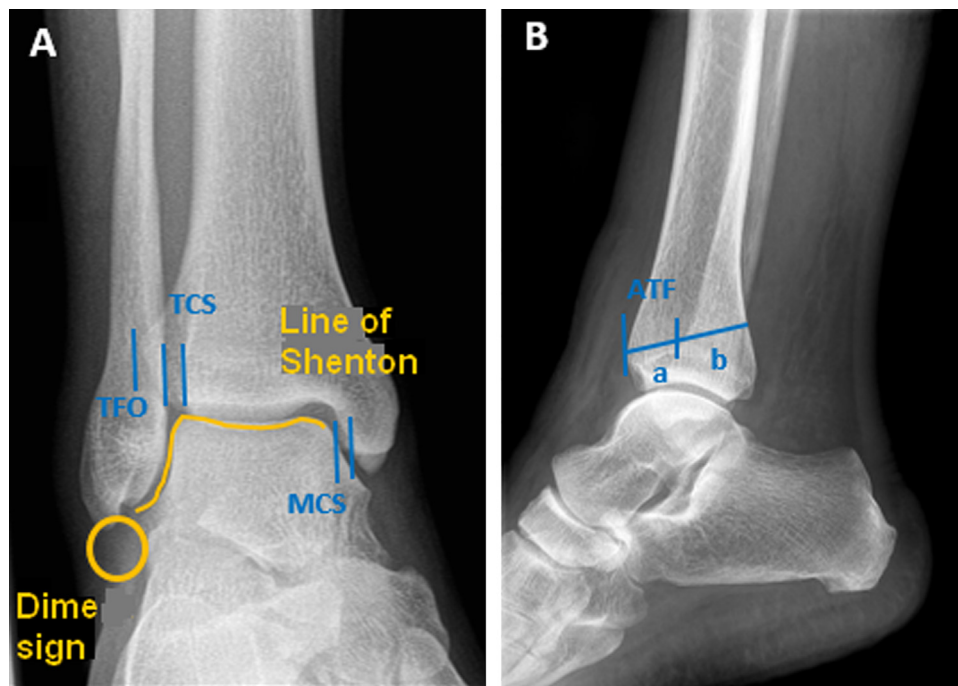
Normal radiographic landmarks seen on a mortise AP view (15° internal rotation) (A) and lateral view (B). A: Mortise AP view; Shenton line: the two articular surfaces must be parallel; Dime sign: a circle can be traced between the tip of the lateral malleolus and the lateral side of the talus; Tibiofibular Clear Space (TCS): < 6 mm, measured between the medial part of the fibular cortex and the anterior lateral cortex of the ankle mortise; Tibiofibular Overlap (TFO): > 1 mm, measured between the medial cortex of the fibula and the most lateral edge of the ankle mortise at the level of the syndesmosis; Medial Clear Space (MCS): < 5 mm; B: lateral view; ATF: Anterior TibioFibular interval; AnteroPosterior TibioFibular (APTF) ratio = a/b (mean is typically 0.94).
